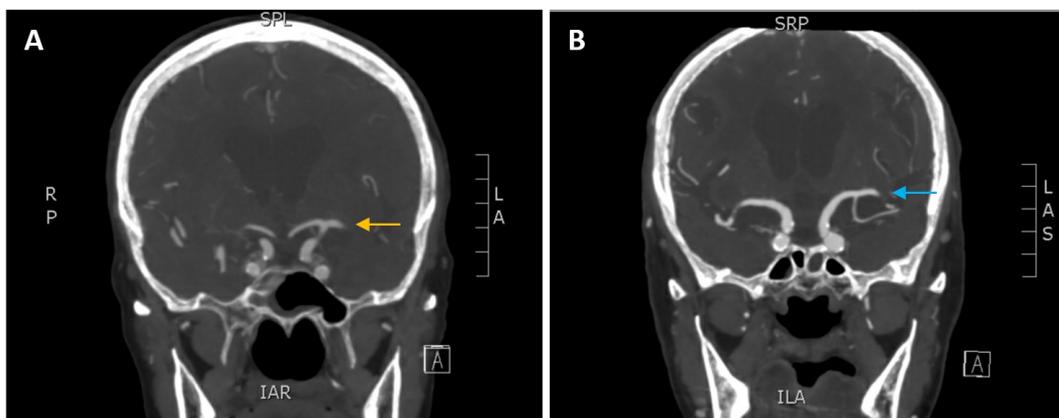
Large and medium vessel occlusion on CTA. A: Large vessel occlusion; left Middle Cerebral Artery M1 occlusion (yellow arrow). B: Medium vessel occlusion; left Middle Cerebral Artery M2 occlusion (blue arrow).
